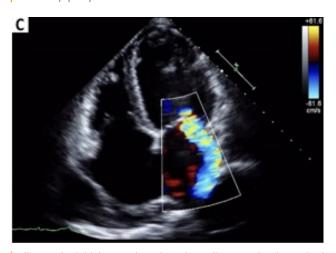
Initial transthoracic echocardiogram showing mitral regurgitation.
